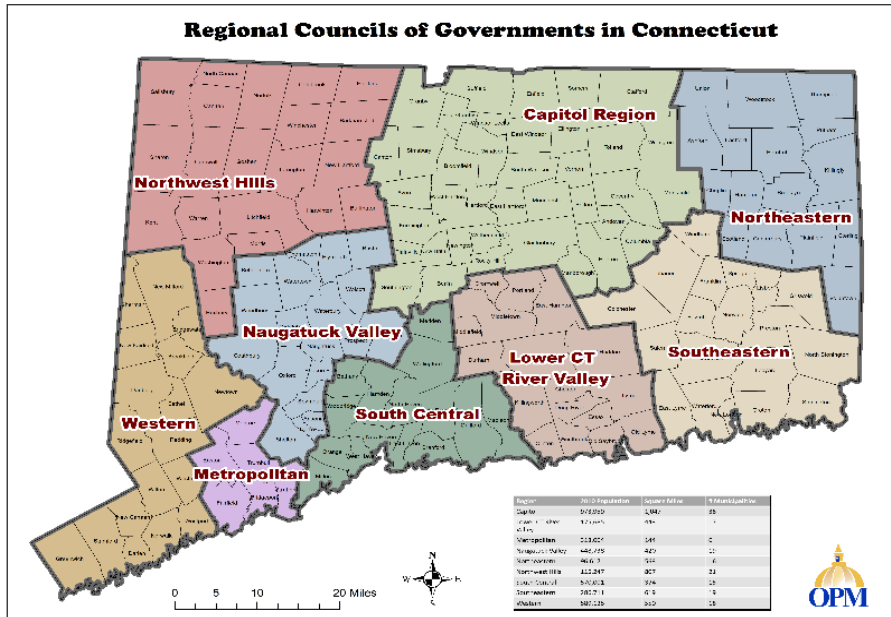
Map of CT regions
